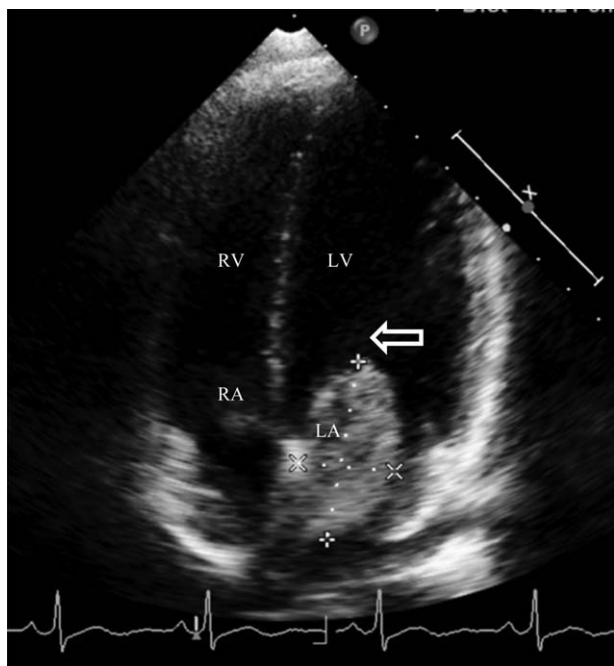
Echocardiography revealed a mass measuring 4.21 cm × 2.25 cm in the left atrium and attached to the interseptum. The mass was myxomatous and movable along the inflow of the mitral valve.
